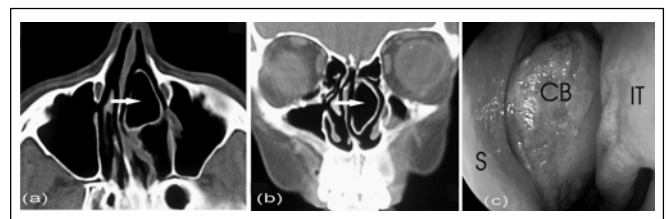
(a) Axial and (b) coronal CT images of a left concha bullosa (white arrow) (c) nasal endoscopic view of the same concha bullosa. S: nasal septum, CB: concha bullosa, IT: left inferior turbinate.
